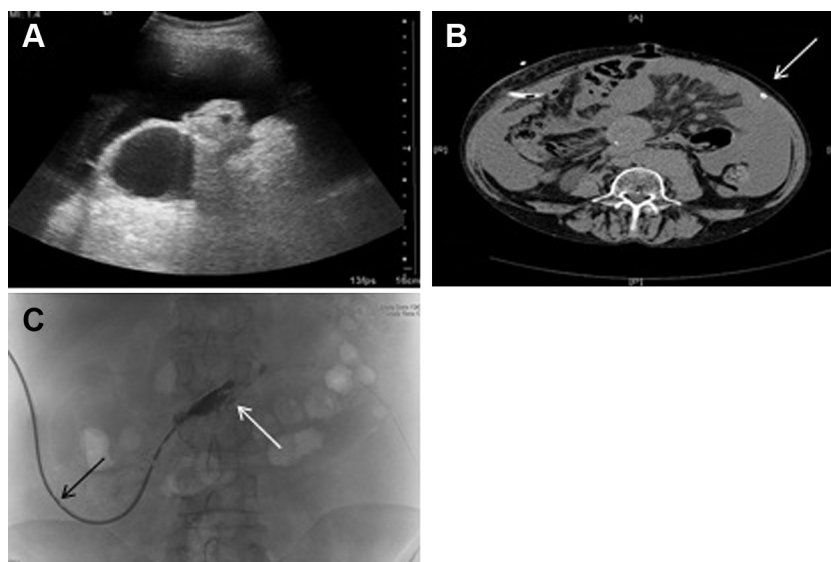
(A) Longitudinal ultrasound scan of the upper abdomen showing uncomplicated ascites overlying bowel loops. (B) Computed tomography scan confirming that the distal catheter (white arrow) lies within the sump of the fluid and not between the omentum. (C) Tubogram showing limited dispersal of contrast beyond the side holes (white arrow) with a guide-wire inserted into the catheter (black arrow) unable to advance suggesting lumen occlusion.
